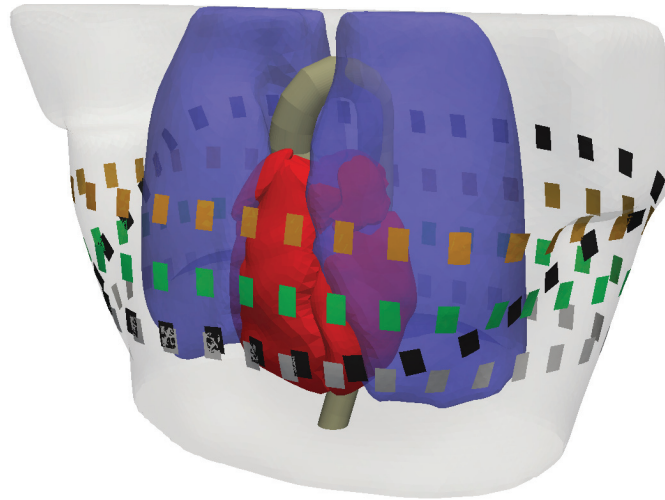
4D thoracic bioimpedance model. The model includes MRI-based dynamic models of the heart and the aorta, and a simplified dynamic model of the pulmonary vasculature. The small rectangles on the periphery of the thorax depict the EIT electrodes. TH: orange belt; TM: green belt; TL: gray belt; OB: black belt. TLM and THM not shown for easier visualization.
